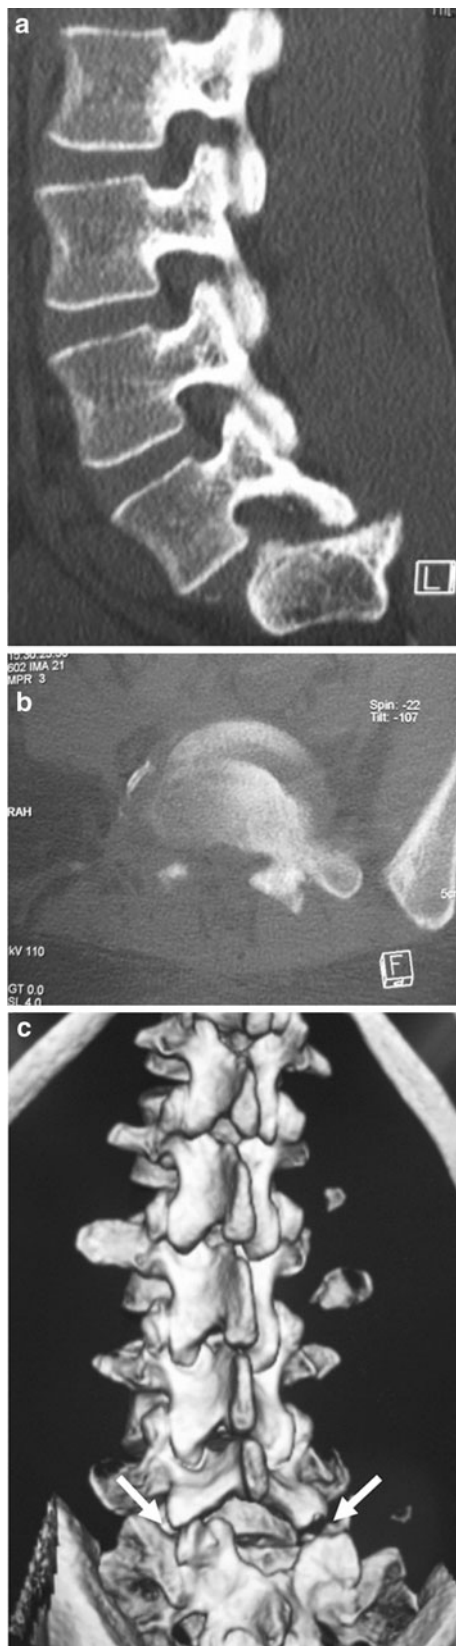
Sagittal (a), axial (b) and 3-dimensional CT (c) reconstruction showing bilateral locked facets of the lumbosacral joint (arrows)
